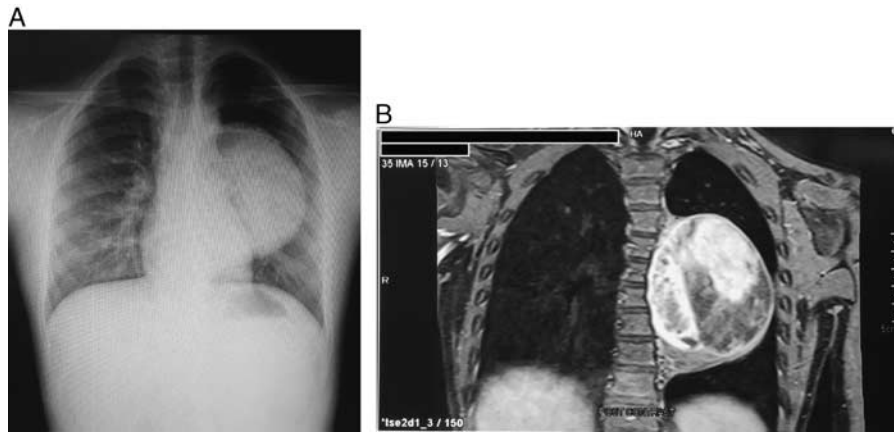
A, Chest x-ray shows large homogenous mass occupying almost half of the left hemithorax. B, Contrast-enhanced computed tomography of the thorax and revealed a large heterogenous enhancing lesion, extending from T4 to T9 vertebrae.
